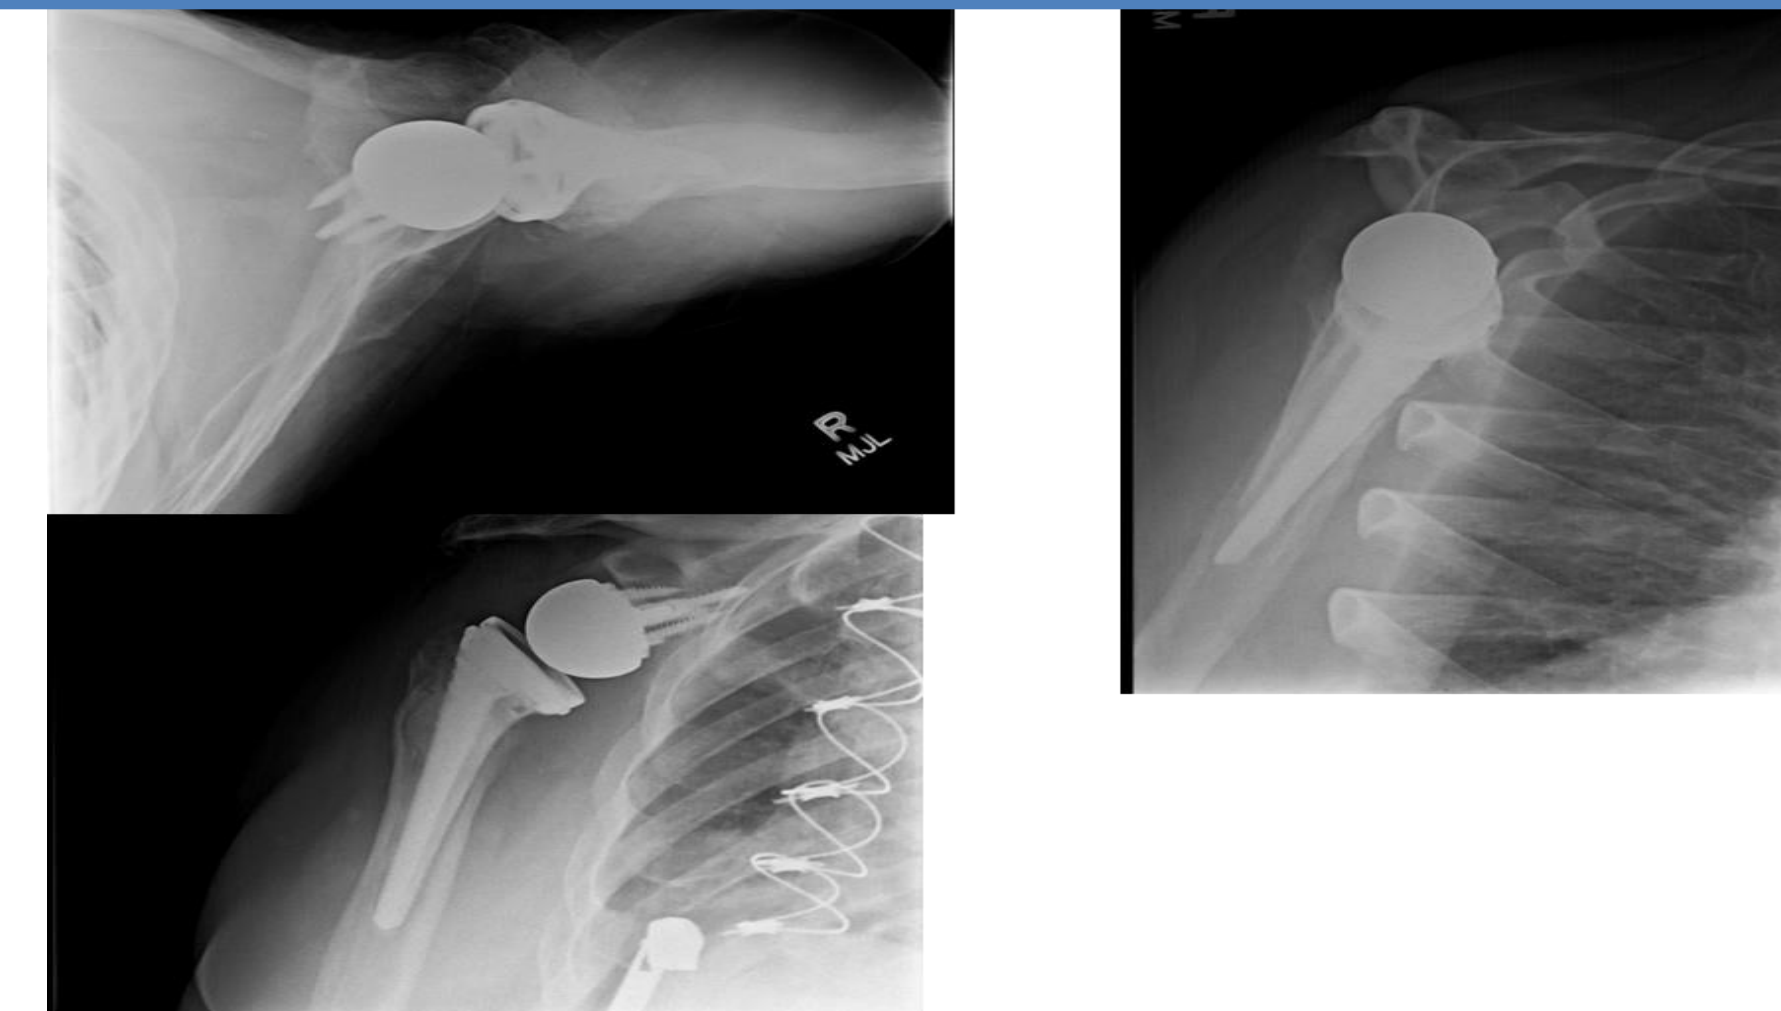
Radiograph of the final reverse total shoulder arthroplasty.
